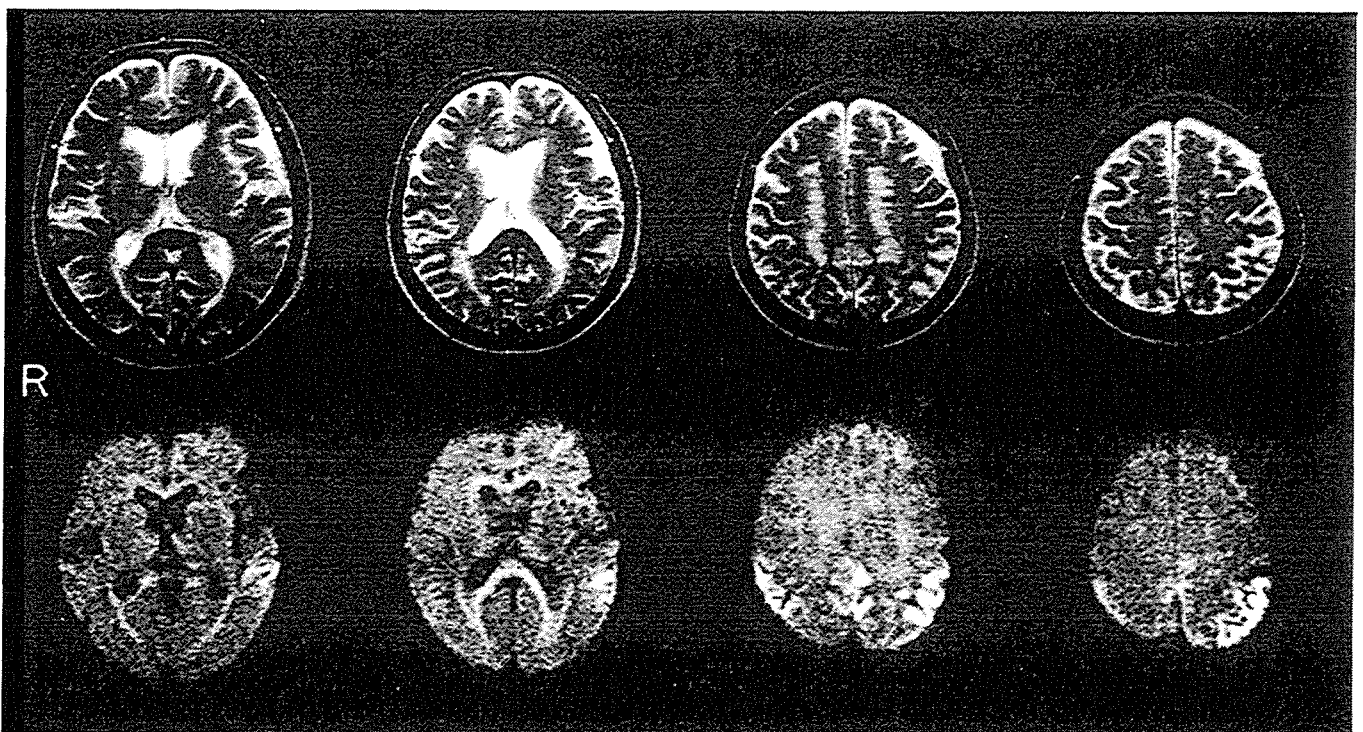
MRI performed 6 months after the emergence of symptoms. An abnormally high signal is seen along the parieto-occipital lobe cortex, predominant on the left side. In the basal ganglia and thalami, no abnormal findings are seen. T₂ (upper row) and diffusion (lower row) weighted images.
